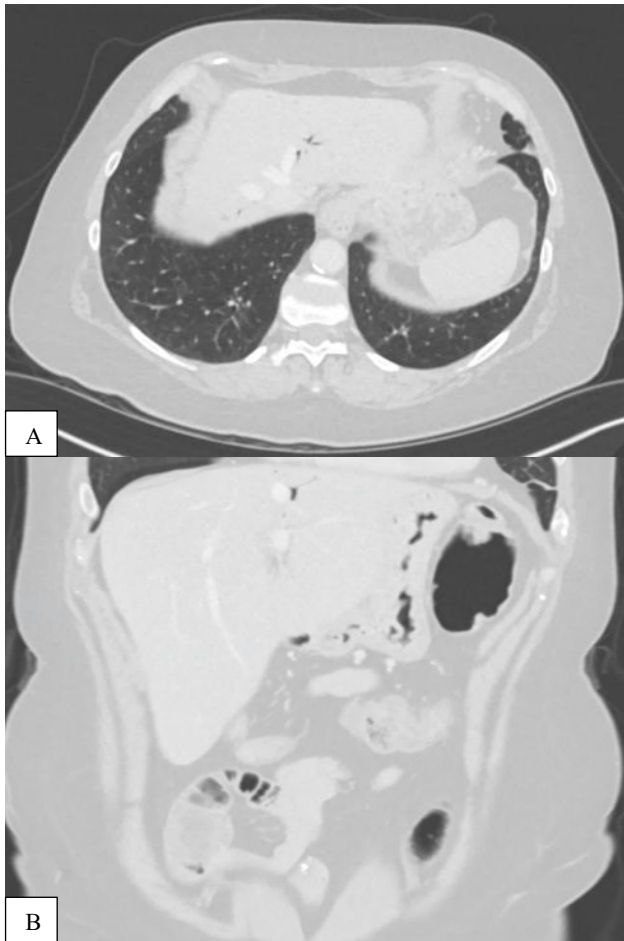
(A and B): Axial slice image (left) and coronal slice image (right) of the abdominal CT with portal venous contrast showing PVG in segment IIA of the liver.
